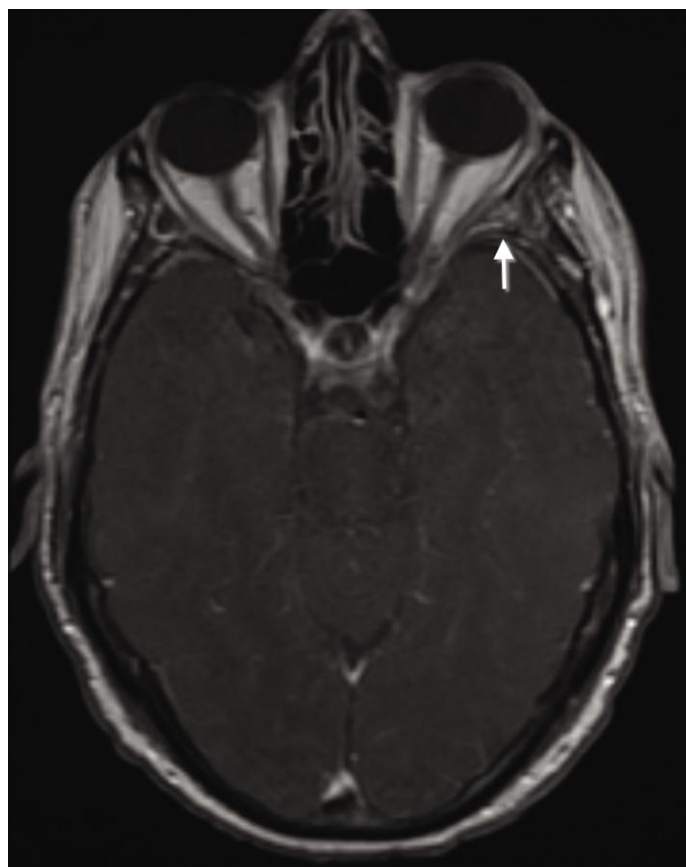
43 year old male with history of HIV and plasmablastic lymphoma underwent repeat brain and orbital MRI at five months after initial presentation and imaging. There is marked improvement of the previously seen orbital left sphenoid enhancing lesion (arrow). Slight residual post gadolinium enhancement is identified. (Protocol: axial T2, TR:5867, TE:81, Slice thickness:5mm, FOV:24cm)
